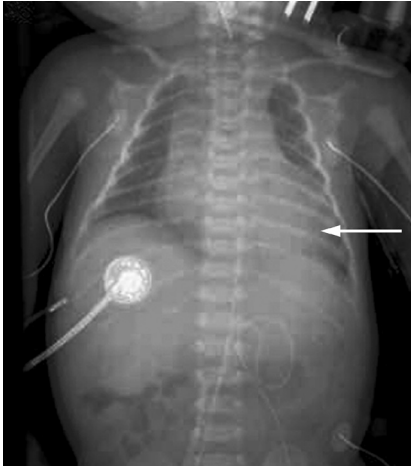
Chest radiograph (anterioposterior view) of a two-day-old neonate.
